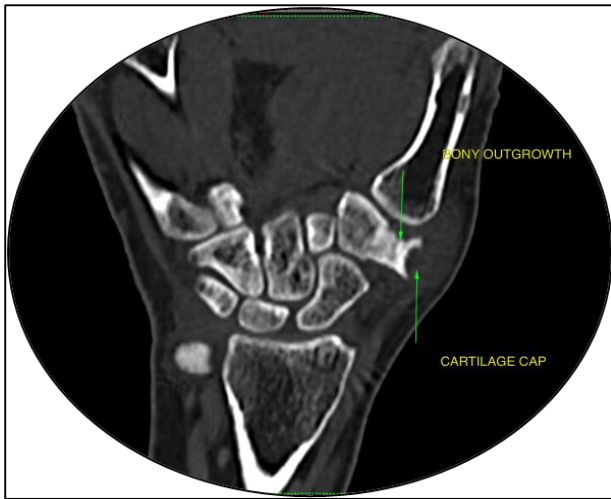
CT scan demonstrating osteochondroma in the left trapezium.
